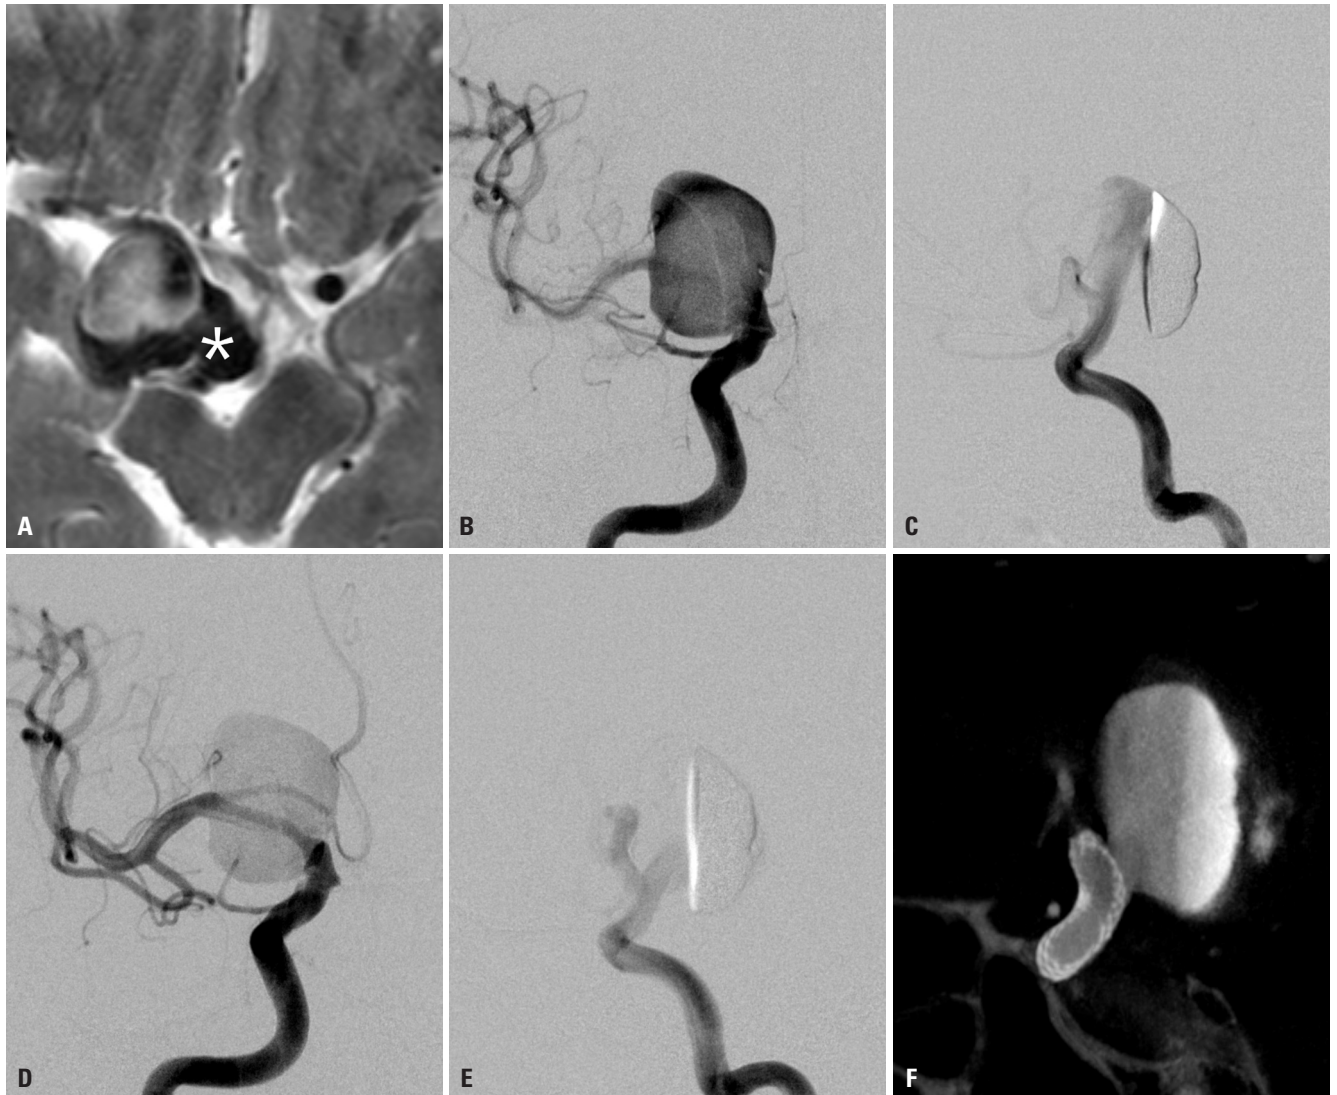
Images of the partially thrombosed aneurysm pre- and post-stenting. (A) Initial T2-weighted magnetic resonance imaging shows a partially thrombosed (asterisk) giant aneurysm in the cavernous segment of the right internal carotid artery. (B and C) Preoperative digital subtraction angiography reveals a giant aneurysm with the inflow jet axis oriented posterosuperiorly toward the aneurysm dome on the sagittal plane. (D and E) Post-treatment completion angiography shows significantly decreased inflow to the aneurysm sac with redirection of the initial inflow jet axis toward the posteroinferior aspect on the sagittal plane. (F) DynaCT identifies the optimal stent position across the aneurysm neck.
